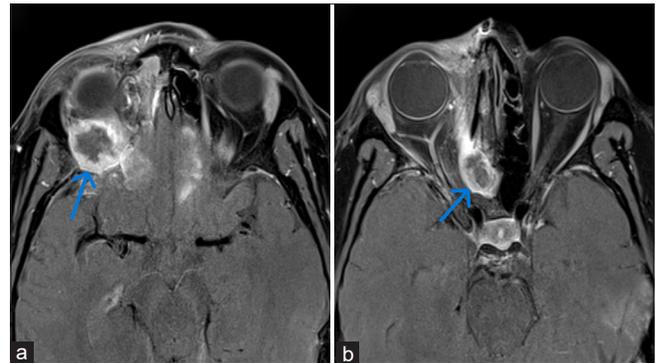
(a-b) Post-contrast T1-weighted axial image showing heterogeneously enhancing mass lesion, the blue arrow shows invasion of (a) intraorbital extraconal compartment of right orbit and (b) right posterior ethmoidal air cells.
